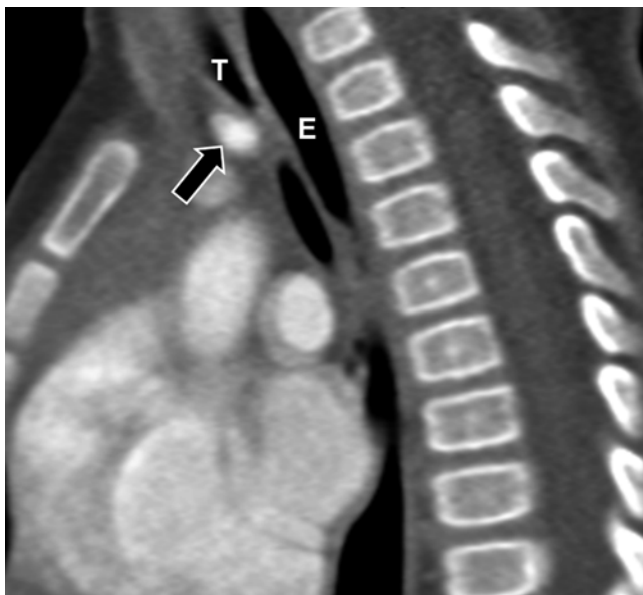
Innominate artery compression in a 14-month-old girl who presented with recurrent cough and severe respiratory distress. Enhanced sagittal CT image shows an anterior compression of the trachea (*T*) due to innominate artery (*arrow*). *E* esophagus
